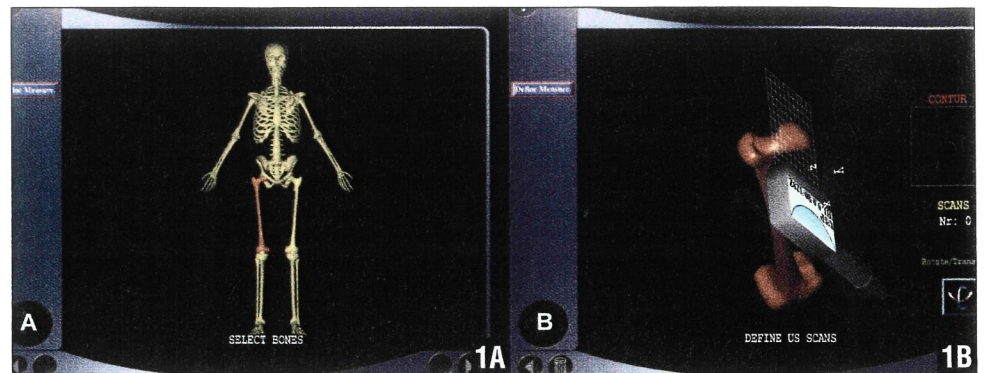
Selecting the skeleton regions to be measured (A). The virtual ultrasound probe is used to define any ultrasound scan. The respective surface contour is displayed simultaneously (B).
